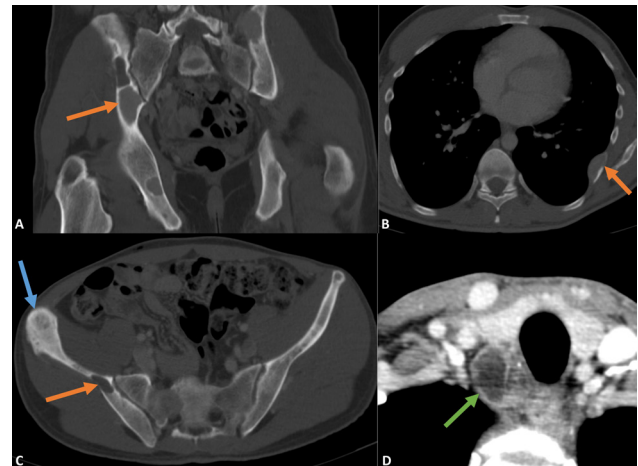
Contrast-enhanced CT of the thorax, abdomen, and pelvis. Coronal (A) and axial (B, C) images in bone window demonstrate multiple lytic lesions in the ribs and pelvis (orange arrows) and a sclerotic lesion in the right iliac wing (blue arrow). Axial image in soft-tissue window (D) demonstrates a hypodense cystic mass posterior to the right thyroid lobe (green arrow), suggestive of a parathyroid tumour.
